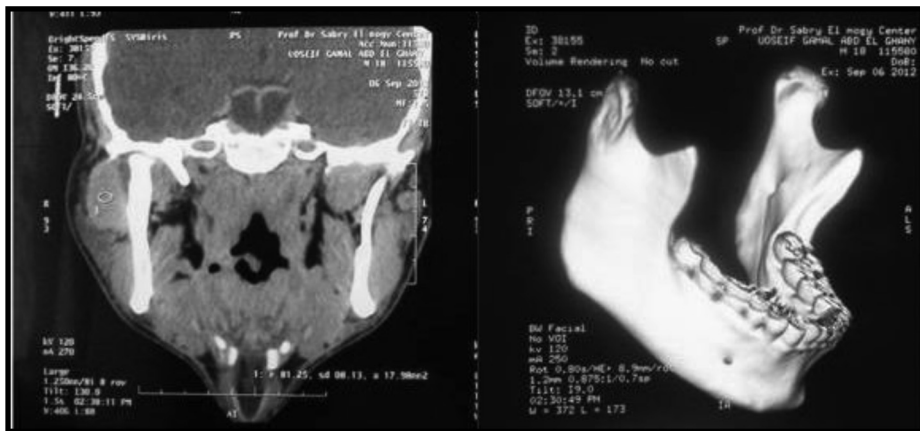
Computed tomography imaging (soft tissue window) and 3DCT showing a well marginated, homogenous mass in the upper part of the parotid gland.
